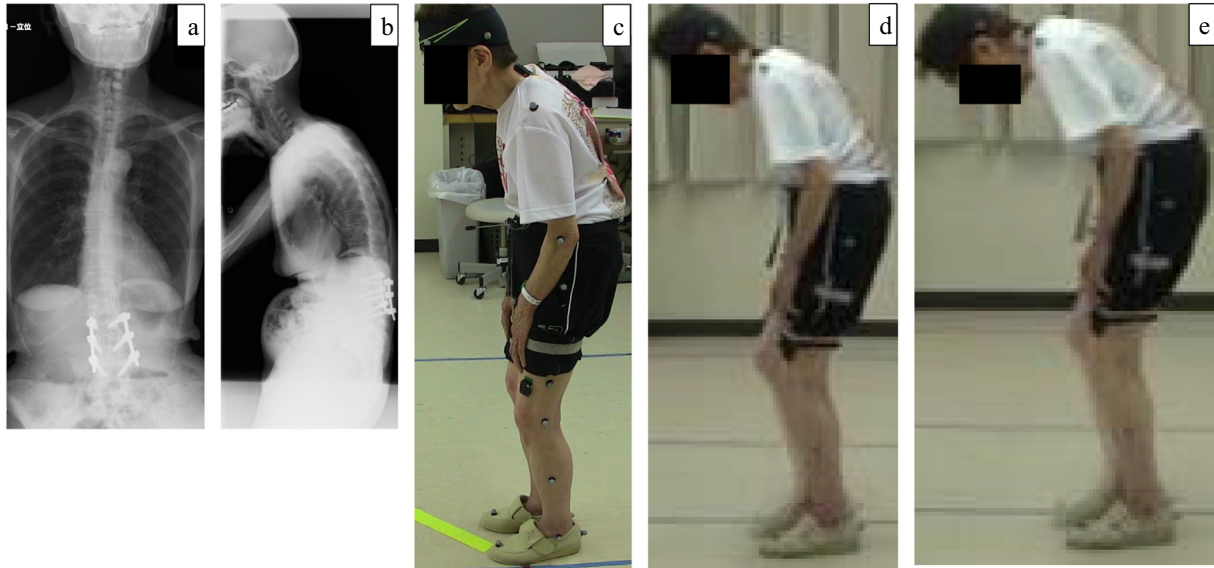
Preoperative radiographs and posture: (a, b) Whole spine radiograph showing severe thoracolumbar kyphosis after lumbar spinal fusion at L2–L4. (c) Lateral posture on standing. (d) Lateral posture during gait analysis immediately after the patient started walking. (e) Lateral posture during gait analysis just before the patient finished walking showed the progression of spinal kyphosis.
